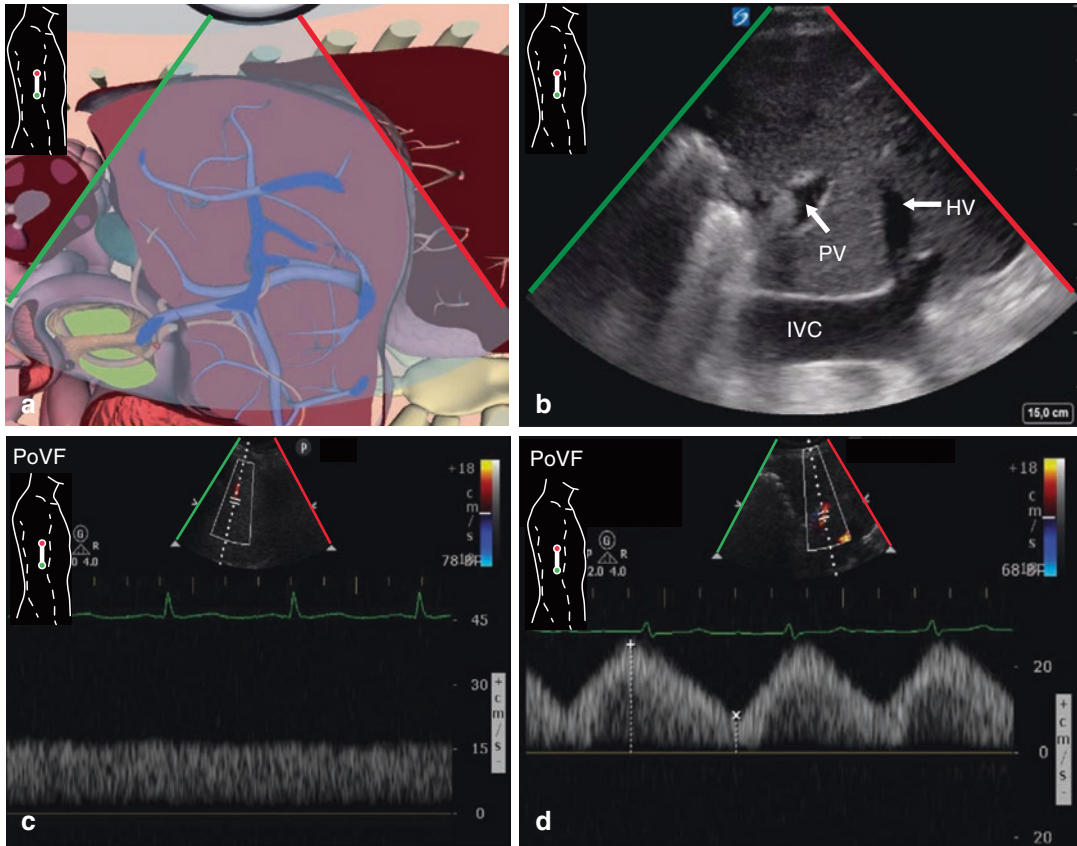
Examination of portal venous flow. (a) Portal venous flow (PoVF) assessment from a posterior axillary line coronal view. (b) Using the same view, the inferior vena cava (IVC), portal vein (PV) and hepatic vein (HV) can be seen. Note the increased echogenicity of the PV wall. (c) Normal portal vein pulsed-wave Doppler has a
